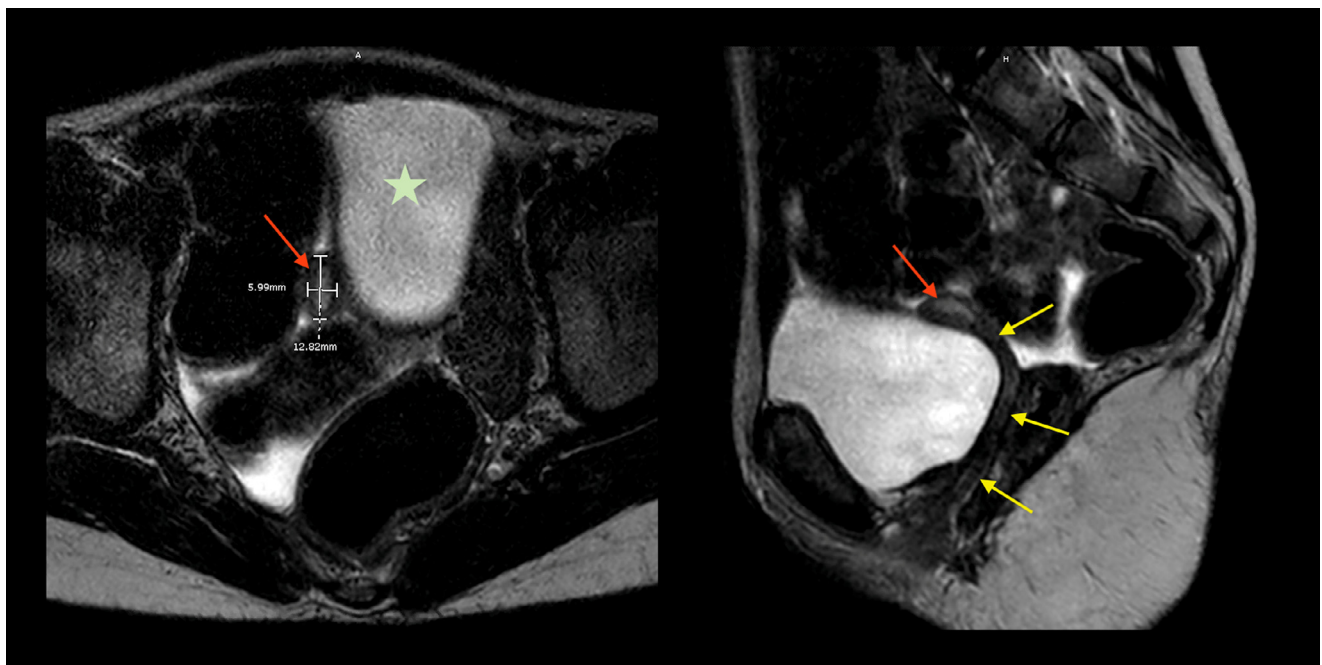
Small field-of-view T2-weighted axial and sagittal MR imaging of the pelvis without contrast demonstrating a tubular/ovoid-shaped structure (red arrow) adjacent to the urinary bladder (green star) which is continuous with a tubular structure containing fluid posterior to the bladder (yellow arrows). (Color version of figure is available online.)
